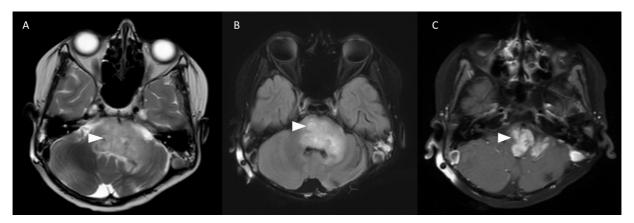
Axial T2-weighted (A), T2/FLAIR (fluid-attenuated inversion recovery) (B), and postcontrast images (C) reveal T2/FLAIR hyperintensities with corresponding postcontrast enhancement in pons, medulla, and left cerebellar peduncle (*arrowheads*).
